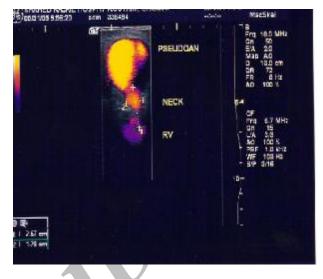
Abdominal ultrasonography of the pseudoaneurysm.
